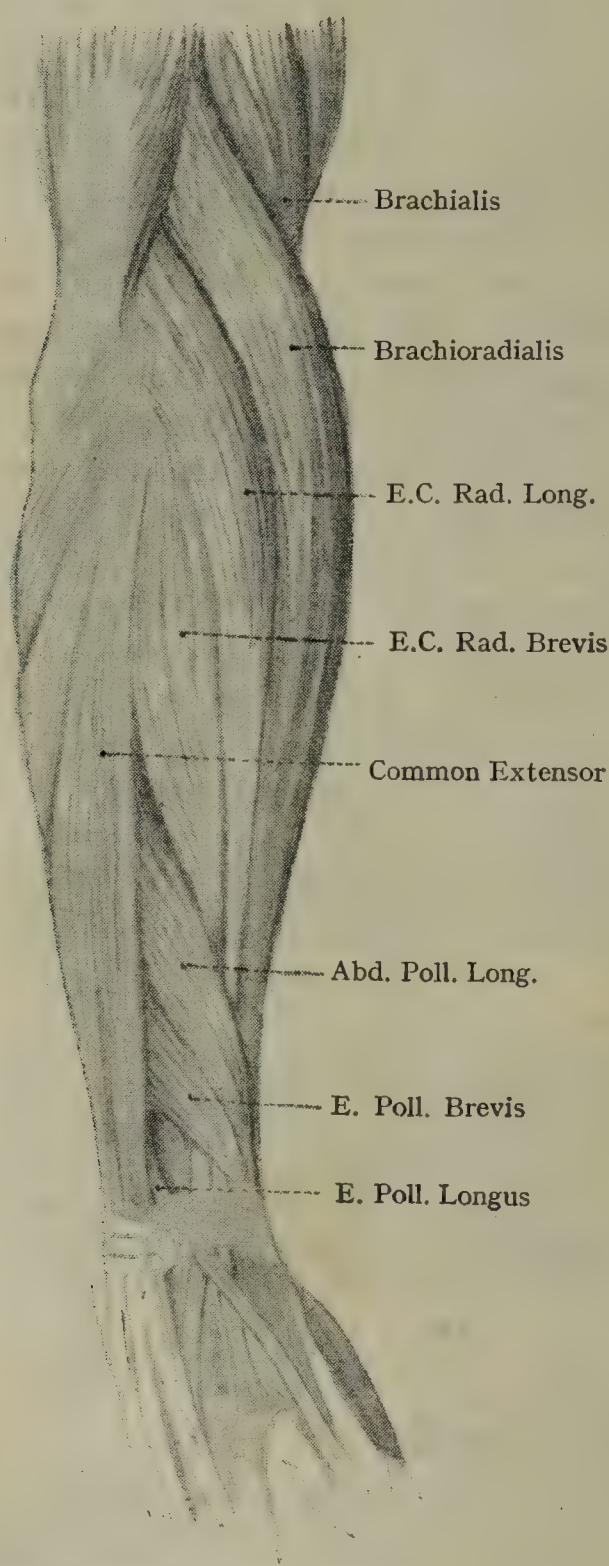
MUSCLES ON LATERAL ASPECT OF FOREARM.
